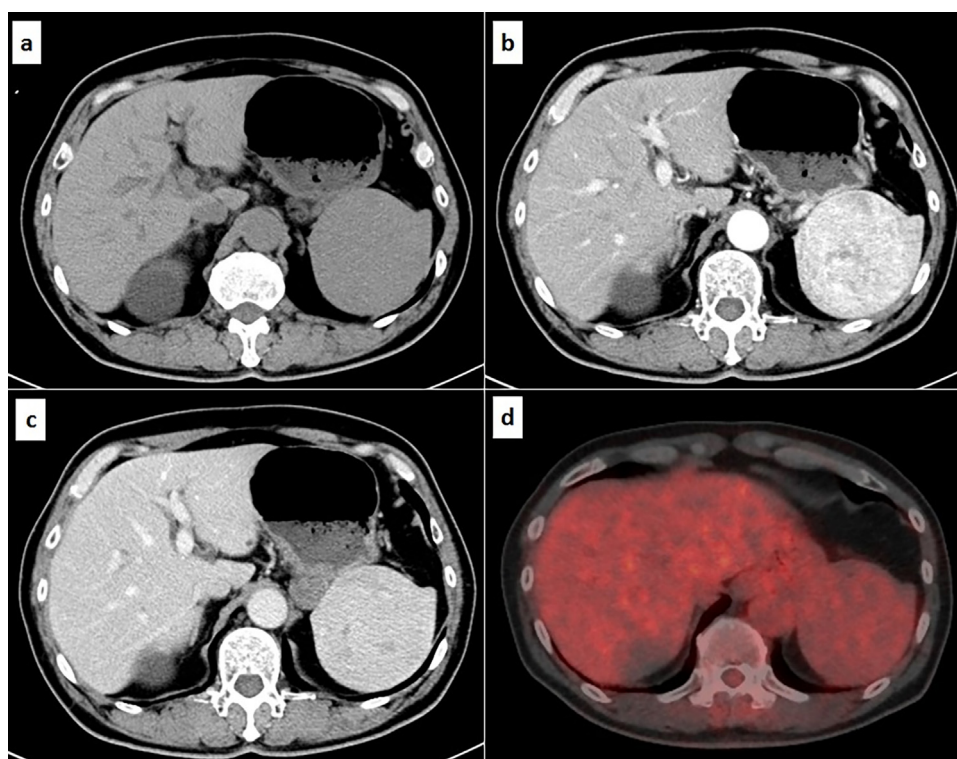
Abdominal computed tomography (CT) revealed an isodense splenic mass (a). Contrast-enhanced CT showed heterogeneous enhancement of a solid splenic mass (8.0 cm) during the arterial phase (b). The mass was isodense compared to normal splenic parenchyma in the portal phase (c). PET-CT showed no significant FDG accumulation within the mass (d).
